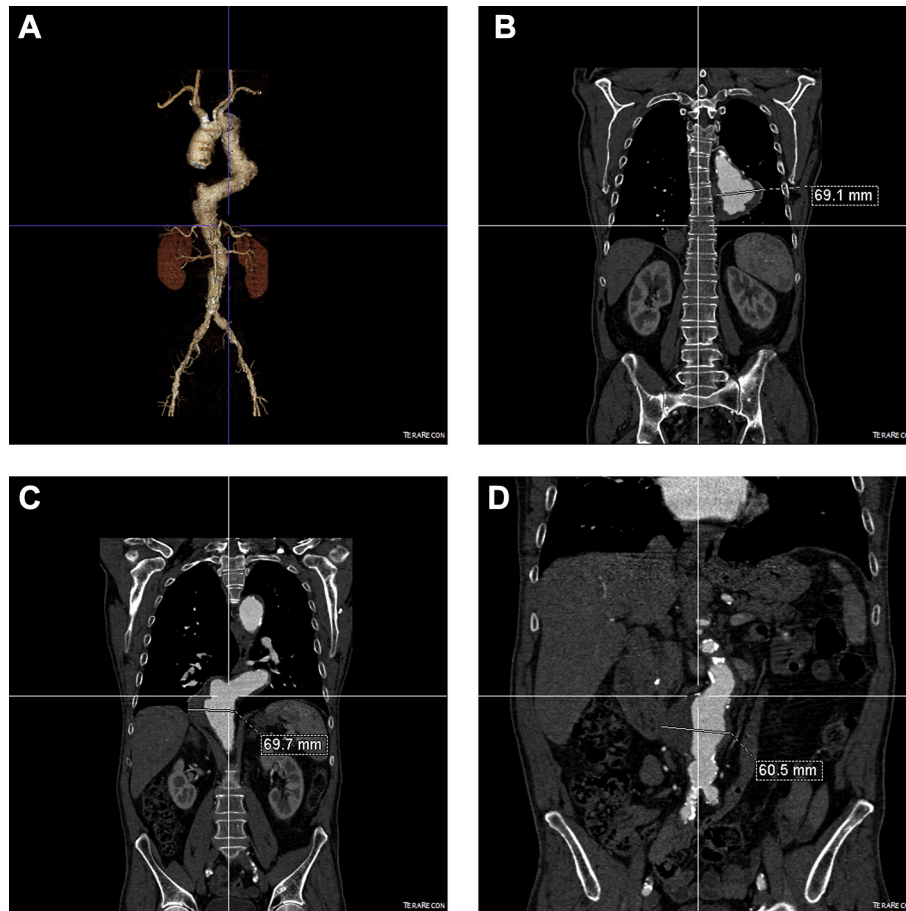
Pre-operative computed tomography three dimensional volume rendering (A) and multiplanar reconstructions showing a 70 mm bifocal thoracic aneurysm (B,C), and a 60 mm juxtarenal aneurysm (D).
